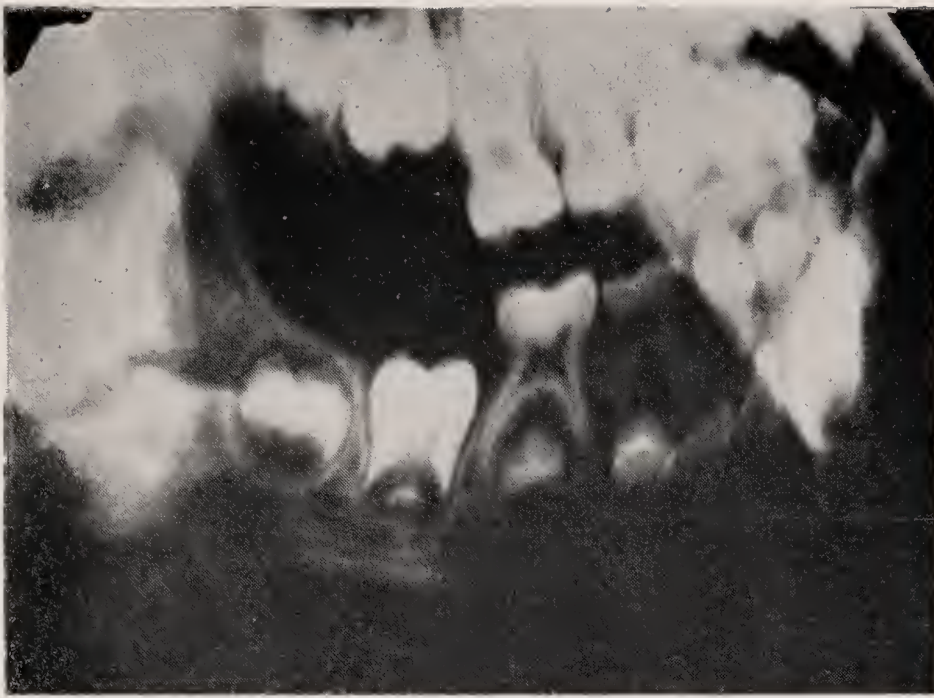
X-rays of same—"no spacing"; therefore, according to Brustin and Leitz, a true type.
